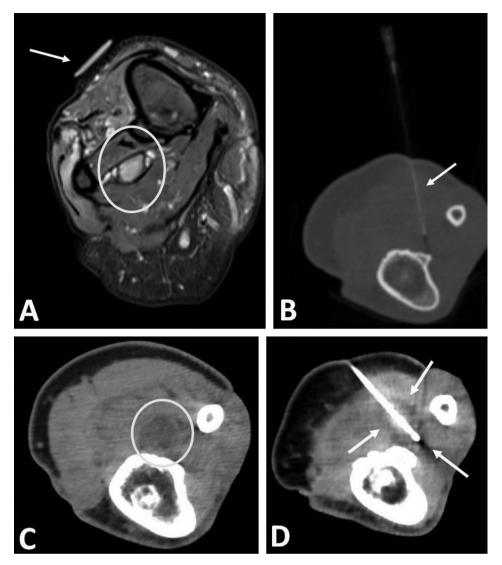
58-year-old man with intractable residual limb pain related to in a below the knee amputation. A. Proton density-weighted MR image in the axial plane at the level of the tibia-fibula demonstrates hyperintense neuroma (circle). Surface marker (arrow) was placed by the patient to indicate the epicenter of his discomfort. B. Intraprocedural CT image obtained in the axial plane during diagnostic injection. A 22-Gauge spinal needle (arrow) is used to deliver Bupivacaine to the suspected pain generator. C. Intraprocedural CT image obtained in the axial plane after intravenous administration of iodinated contrast material demonstrates the injected mixture surrounding the neuroma (circle). D. Intraprocedural CT image obtained in the axial plane shows the cryoprobe at the neuroma level and the ice covering the lesion (arrows).
